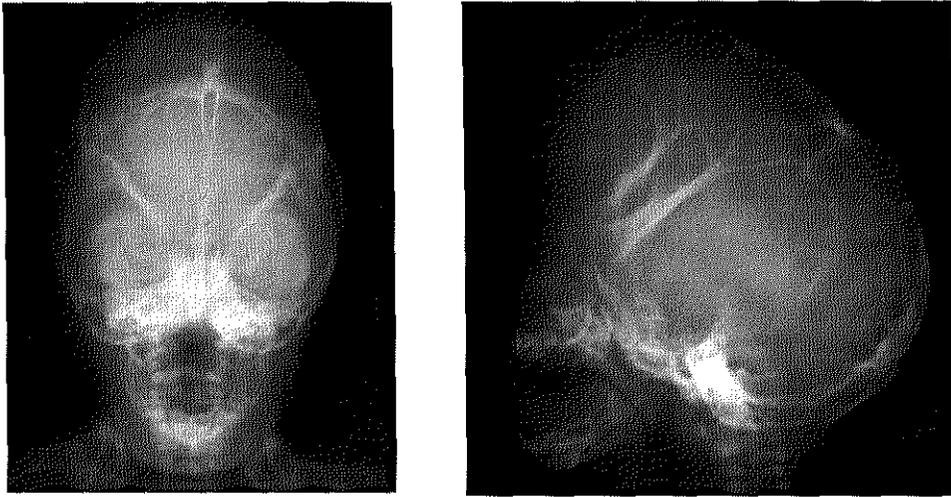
X-ray of a patient with a cloverleaf skull. In anteroposterior direction the skull has the shape of the three leaves of a clover, formed by the bulging temporal bones bilaterally. The lateral view shows *impressionses digitatae*, suggestive of increased intracranial pressure.
